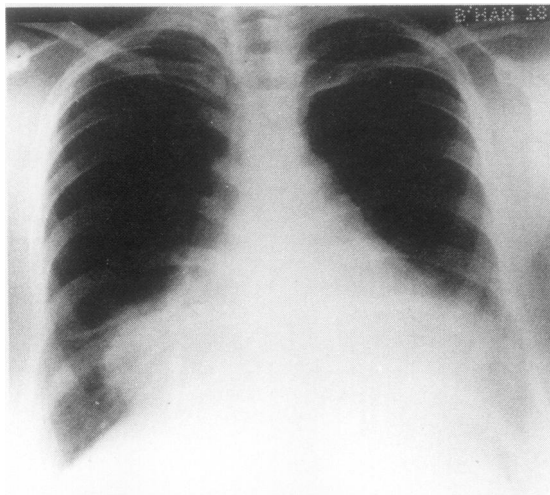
Chest radiograph showing a pericardial effusion and bilateral pleural effusions.
